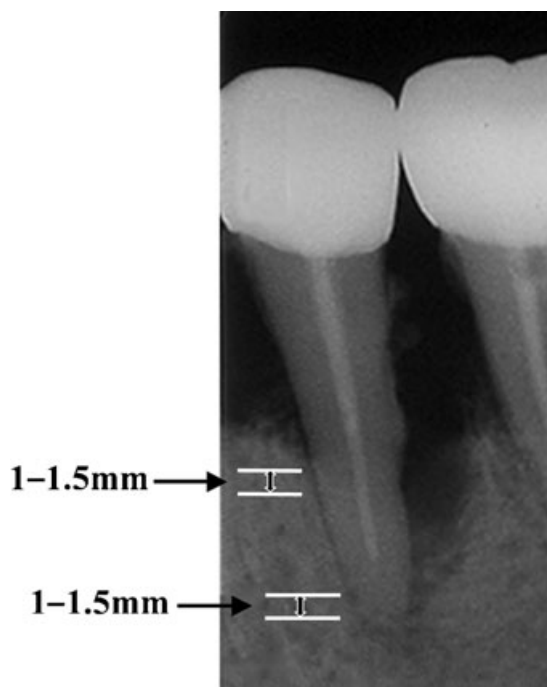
Radiographic image of a tooth diagnosed as chronic periodontitis. The tooth had pockets deeper than 5 mm, together with severe vertical alveolar bone loss, and the deepest pocket was very close to the root apex. The periodontal ligament sample from a patient with chronic periodontitis was prepared from the periodontal ligament attached to the cementum of extracted teeth, corresponding to the periodontal ligament on the opposite side of the deepest pocket. When preparing the sample using a sharp blade, marked lengths, as shown in the figure, were avoided.
